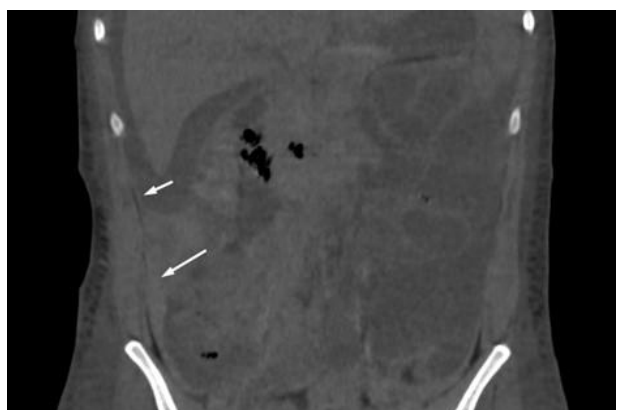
CT abdomen: coronal section with arrow showing peritoneal thickening]
